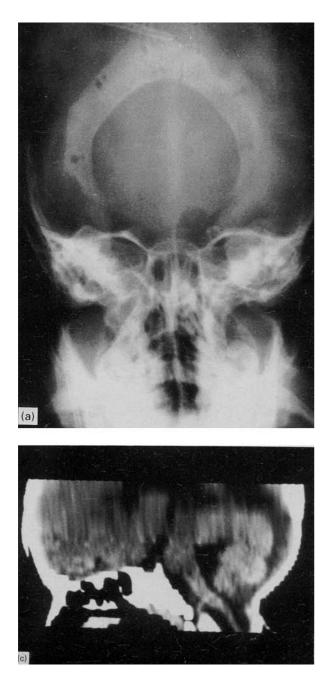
(a) Preoperative X-ray antero-posterior. Note: huge occipital defect ( $9 \times 5$  cm) confluent with foramen occipitale magnum in a 2-year-old girl suffering from occipital encephalocele. (b) CTscan. Same child as Fig. 9a. Note: occipital bony defect after resection of the occipital encephalocele.
